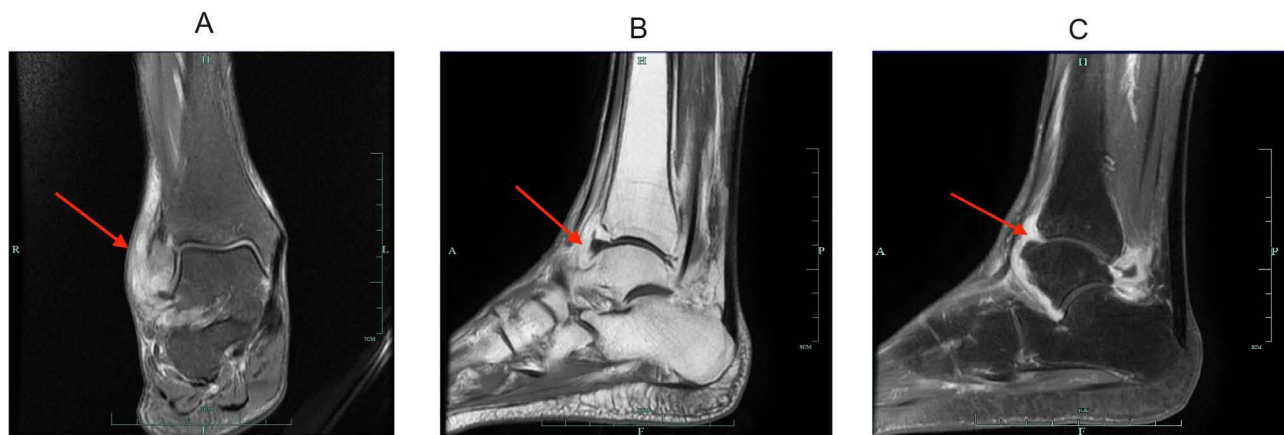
MRI results of right ankle joint on the second day of hospitalization. (A) T2WI coronal view of the right ankle joint. The red arrow shows significant soft tissue swelling around the right lateral malleolus. (B) T1WI sagittal view of the right ankle joint. The red arrow shows the formation of abscess in the right ankle joint. (C) T2WI sagittal view of right ankle joint. The red arrow shows the formation of abscess in the right ankle joint cavity.
